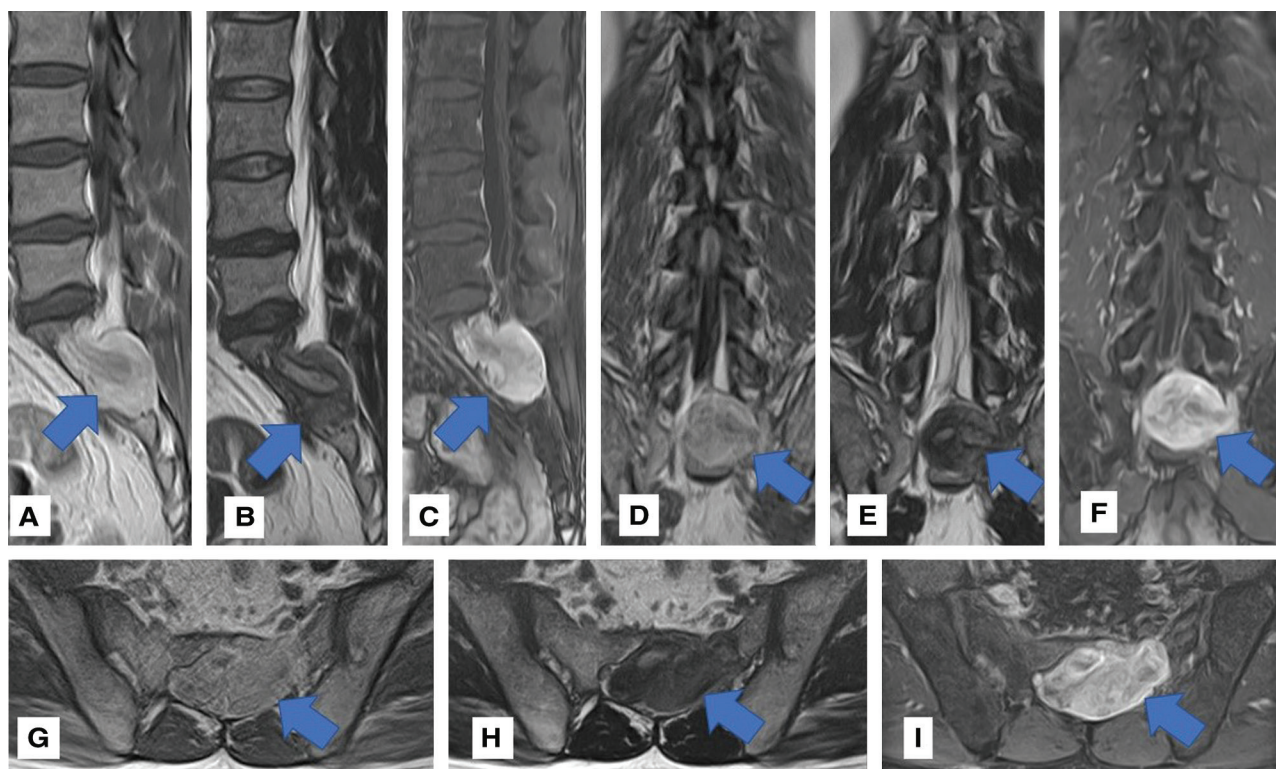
MRI of lumbosacral spine revealed an irregular-shaped destructive mass occupying spinal canal in the sacrum (arrow). The lesion was hyperintense on T1-weighted MRI (T1WI; A, D, G), and hypointense on T2-weighted MRI (T2WI; B, E, H), which are characteristic MRI signal intensity for melanotic schwannoma. Contrast-enhanced T1-weighted MRI (T1CE; C, F, I) demonstrated remarkable contrast enhancement. MRI: magnetic resonance imaging, T1WI: T1-weighted image, T2WI: T2-weighted image.
